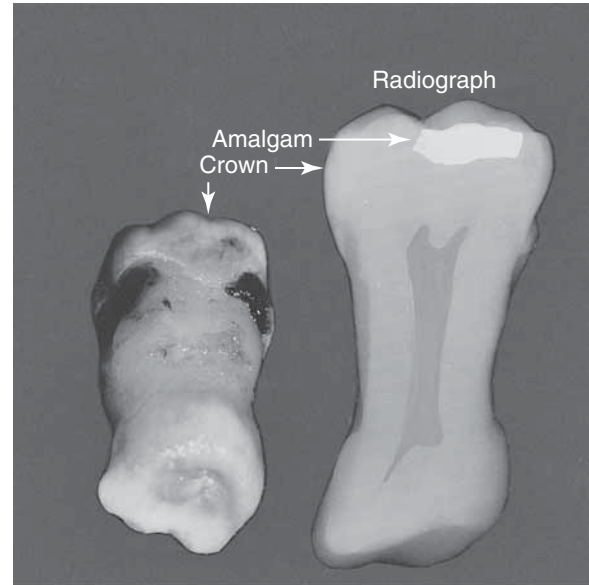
Taurodontia. Photograph of extracted tooth on left; radiograph on right. (Courtesy of Professor Rudy Melfi, D.D.S.)
